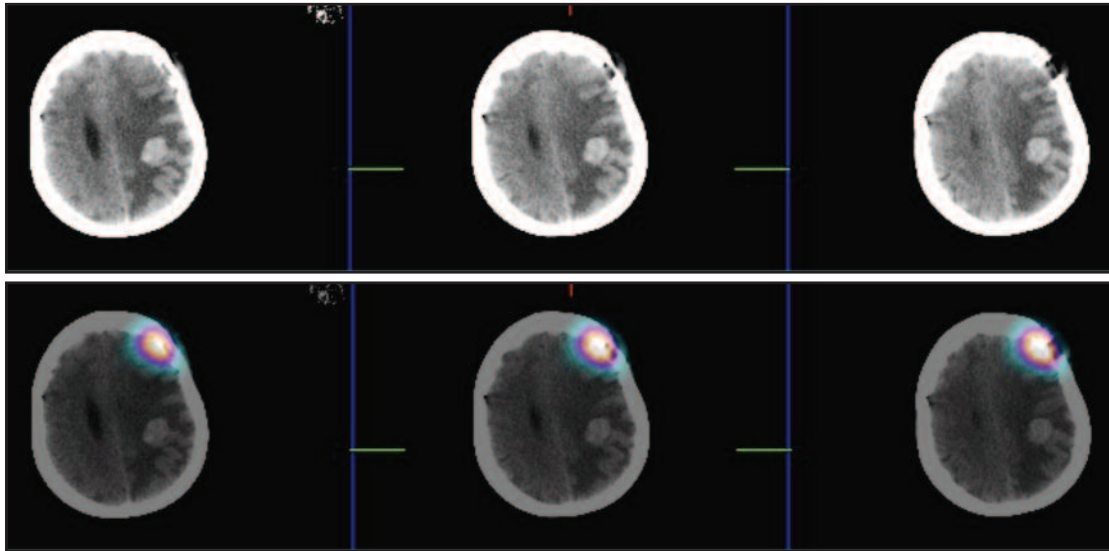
Axial CT and fused SPECT-CT images showing RAI avid metastatic lesion at the site of previous craniectomy on left frontal bone and a non-RAI avid intracranial metastatic lesion at left parietal region with intense surrounding white matter oedema.
